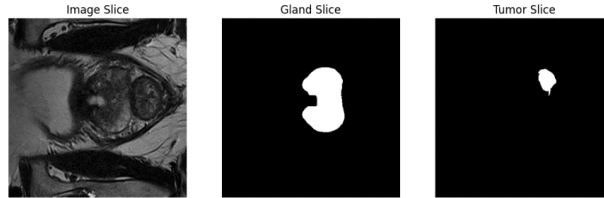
Example of Prostate158 MRI slice
